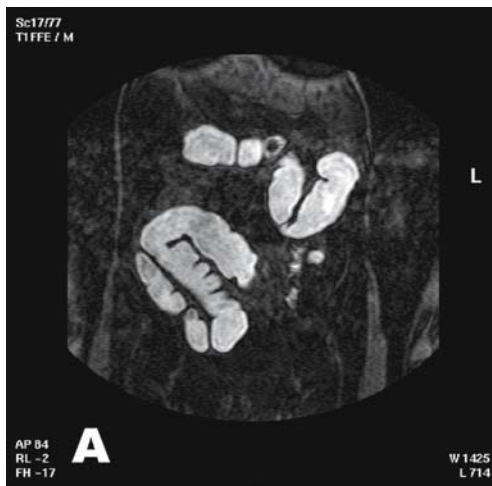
MR colonography. A, Bright lumen technique: 3D GRE sequence with water-gadolinium enema. B, Virtual colonoscopy of normal ascending colon. C, D, Combined bright and black lumen technique: C, contrast-enhanced 3D spoiled T1-weighted GRE image and, D, nonenhanced 3D spoiled and balanced GRE image.
